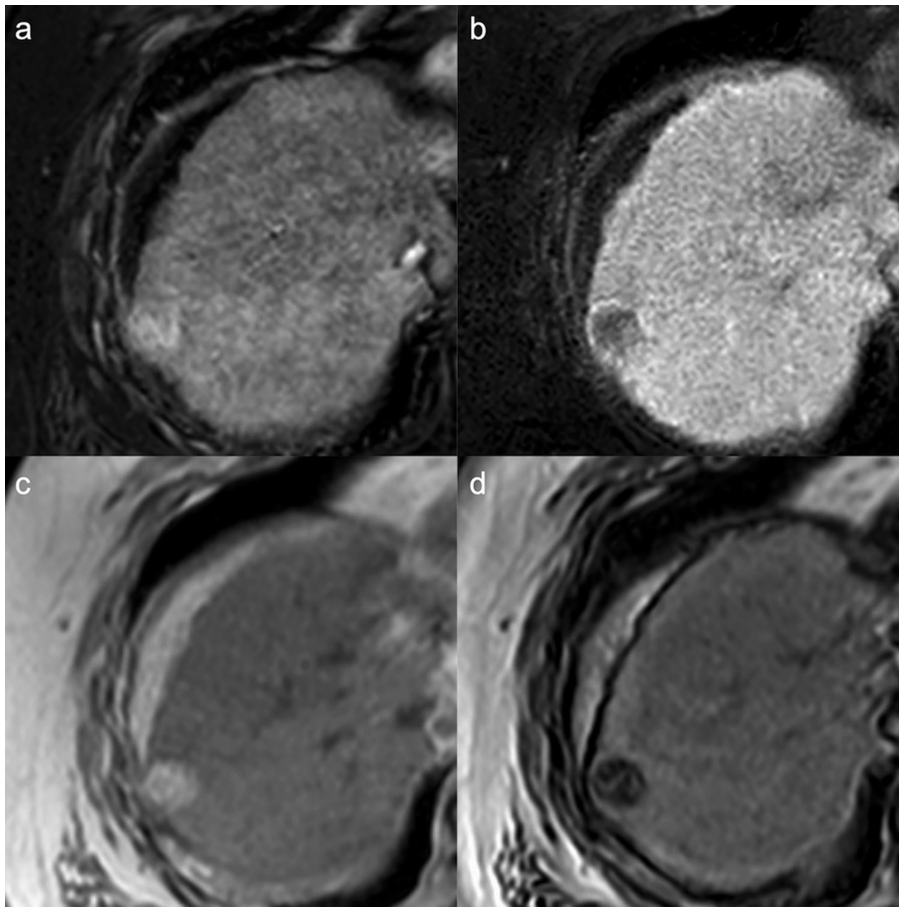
MR images from a 70-year-old male of non-alcoholic steato-hepatitis-related steatotic hepatocellular carcinoma. The nodule in the segment VIII shows hyperenhancement on the arterial phase (a), hypointensity on the portal venous phase (not shown), transitional phase (not shown), and hepatobiliary phases (b). In-phase T1-weighted gradient-echo MR image (c) shows a well-defined hyperintense and the opposed-phase T1-weighted gradient-echo MR image (d) reveals a drop in the signal intensity, which indicates the presence of fat.
